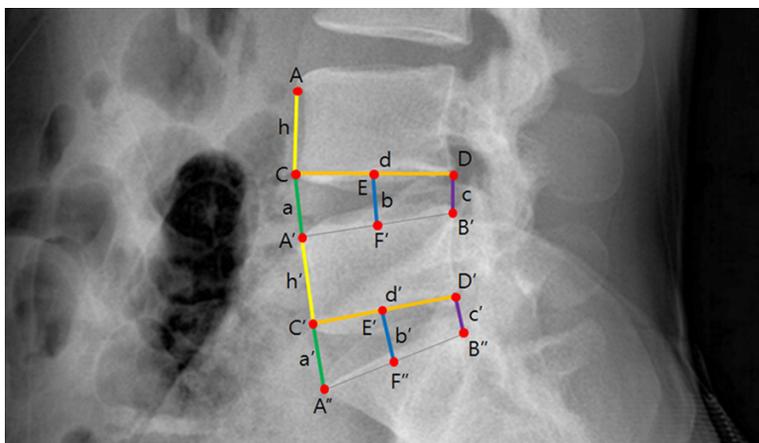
Intervertebral disc space height and vertebral body length and height as measured on lateral L-spine X-ray.
